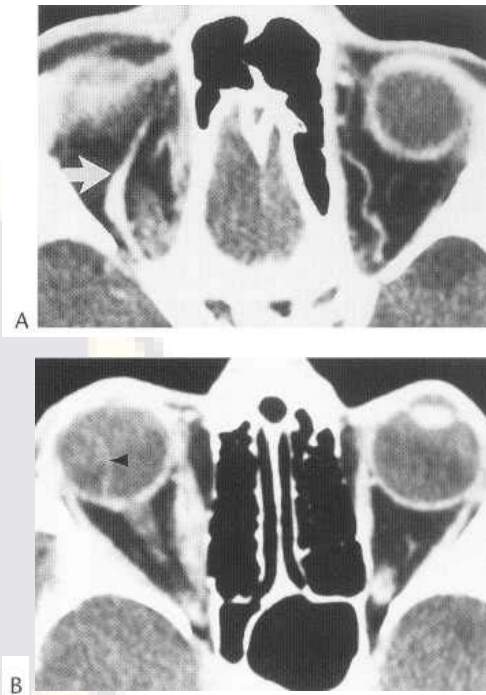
Carotid-cavernous fistula. Enhanced axial CT image (A) demonstrates enlargement of right superior ophthalmic vein (arrow). Image at lower level (B) demonstrates engorgement of right medial rectus muscle as well as elevation of choroid (arrowhead) by suprachoroidal effusion resulting from orbital venous hypertension.
